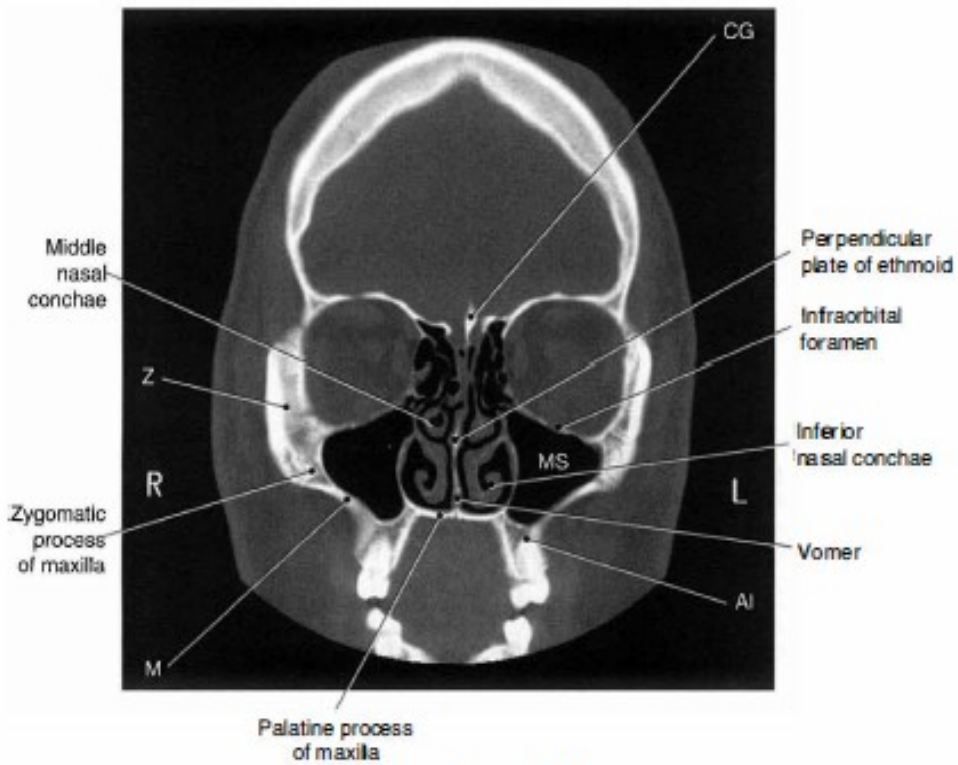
Coronal CT scan of maxillary and zygoma (Lorrie Kelly 2007)
